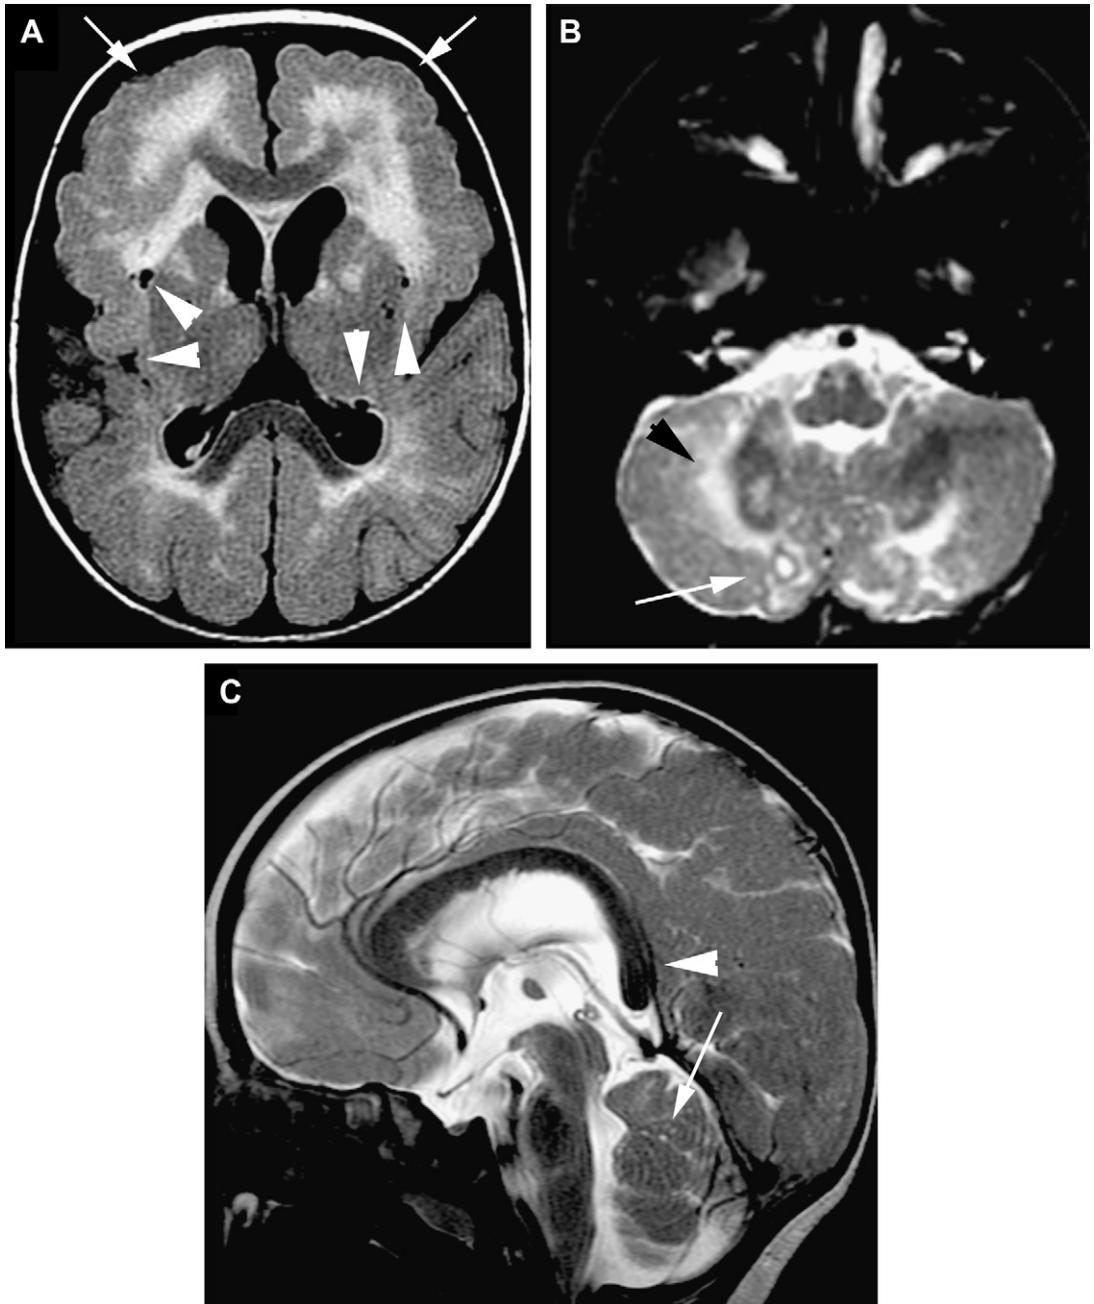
Fukuyama congenital muscular dystrophy. (A) Axial FLAIR. Polymicrogyria-like appearance of the frontal cortex bilaterally (*arrows*), with abnormal myelination that predominates anteriorly but also affects the posterior part of the hemisphere. Microcysts are seen in the external capsules (*arrowheads*). (B) Axial T2, cerebellum. Abnormal myelination (*black arrowhead*) and cystic changes (*white arrow*). (C) Midline sagittal T2. Extended, verticalized splenium (*arrowhead*); microcysts in vermis (*arrow*).
